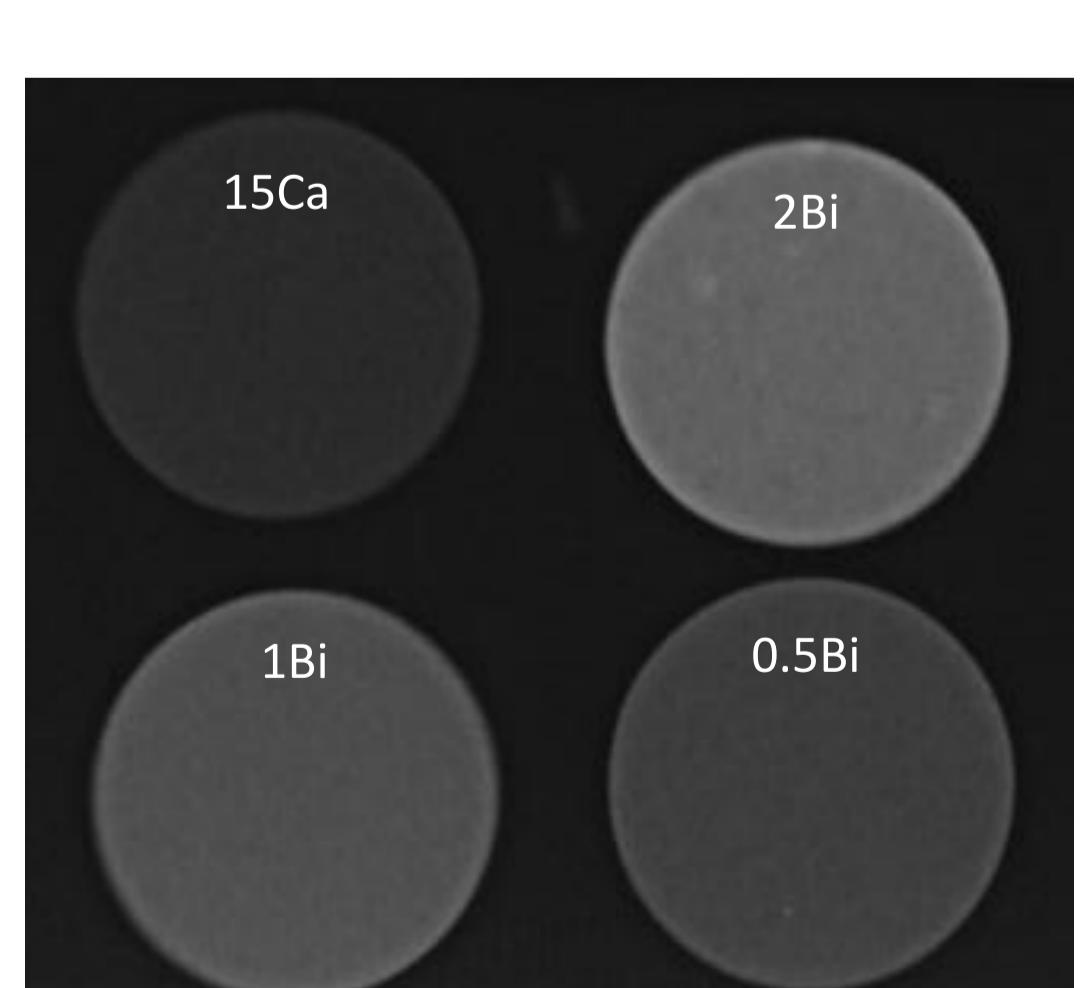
X-ray radiographic images of sample pellets.
